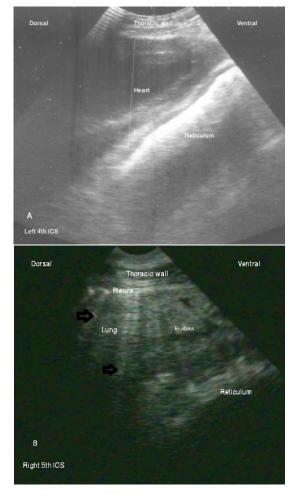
Sonogram of herniated buffalo's reticulum at thoracic cavity (heart and lung) imaged from left 4th ICS (A) and right 5th ICS (B). Herniated reticulum appears undulating (A) and half-moon shape (B). The comet tail artifact (arrows) and hypoechoic exudates indicate adhesion between lung and herniated reticulum (B).
